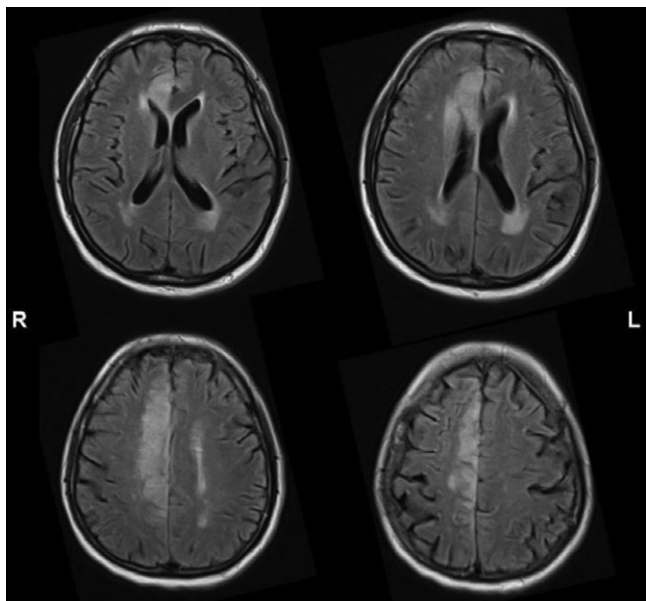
Horizontal T2-fluid-attenuated inversion recovery (FLAIR)-weighted MRI scan three days after stroke onset showed an extended stroke in the territory of the ACA but no ischemic lesions in middle or posterior cerebral artery territory (slice thickness: 5 mm).
